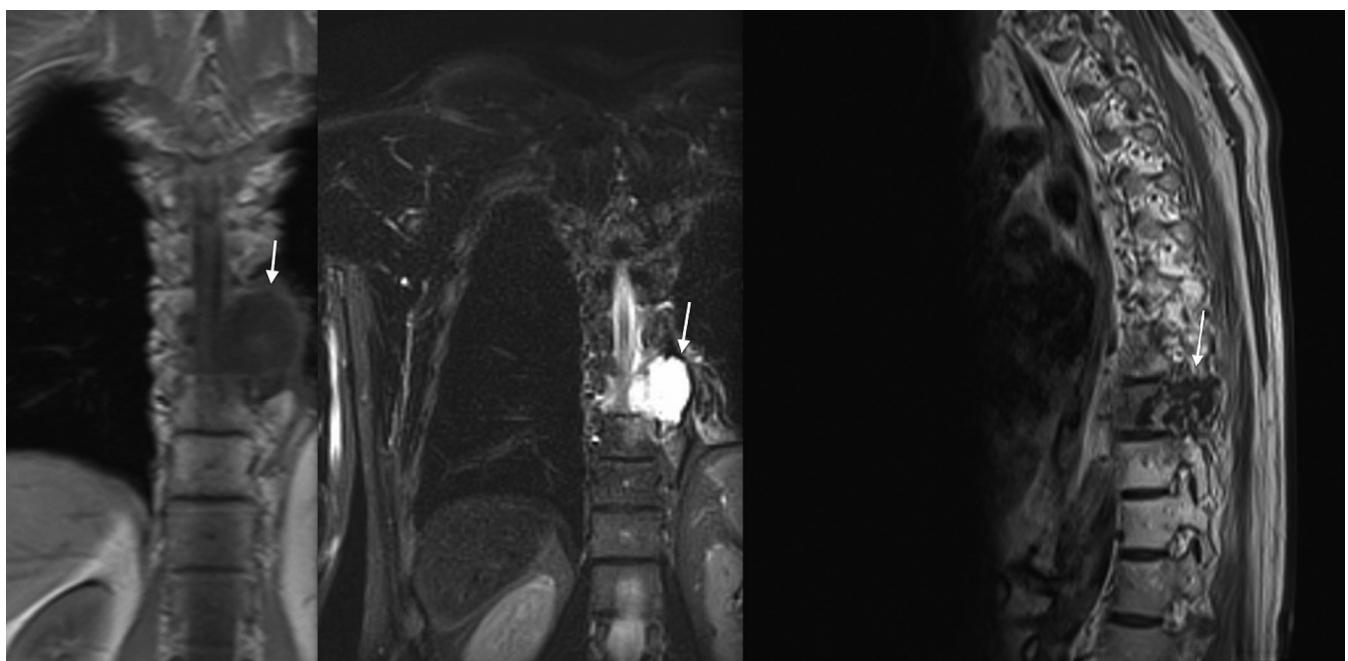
Coronal T1-weighted (Left) hypointense and T2-weighted (Middle) hyperintense images show the cystic-necrotic lobulated mass lesion at the level of the T9 paravertebral space. Also, the postcontrast T1-weighted sagittal image (Right) showed rim enhancement.
